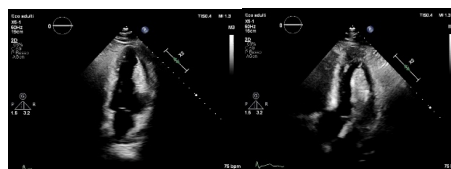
Transthoracic echocardiogram (2 and 3 chamber view) showing a pedunculated lobular mass on left ventricular cavity.
